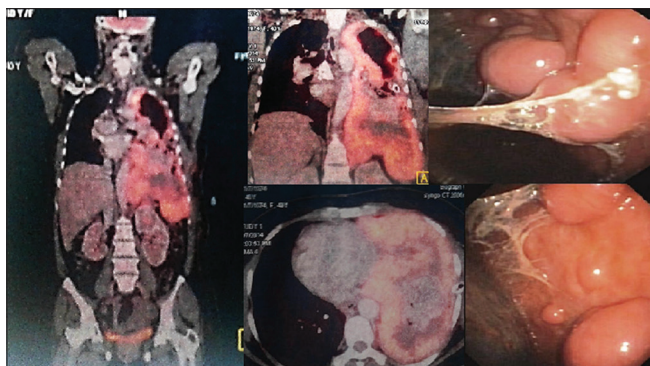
PET CT demonstrating FDG uptake in the pleura, corresponding thoracoscopic pictures of the pleural masses
